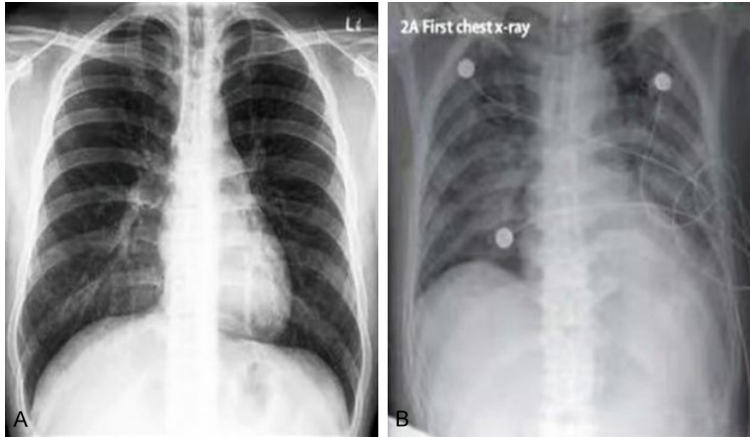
Chest radiographs. A: Chest radiograph of normal people; B: Chest radiograph of a patient with early-mid-stage COVID-19.
